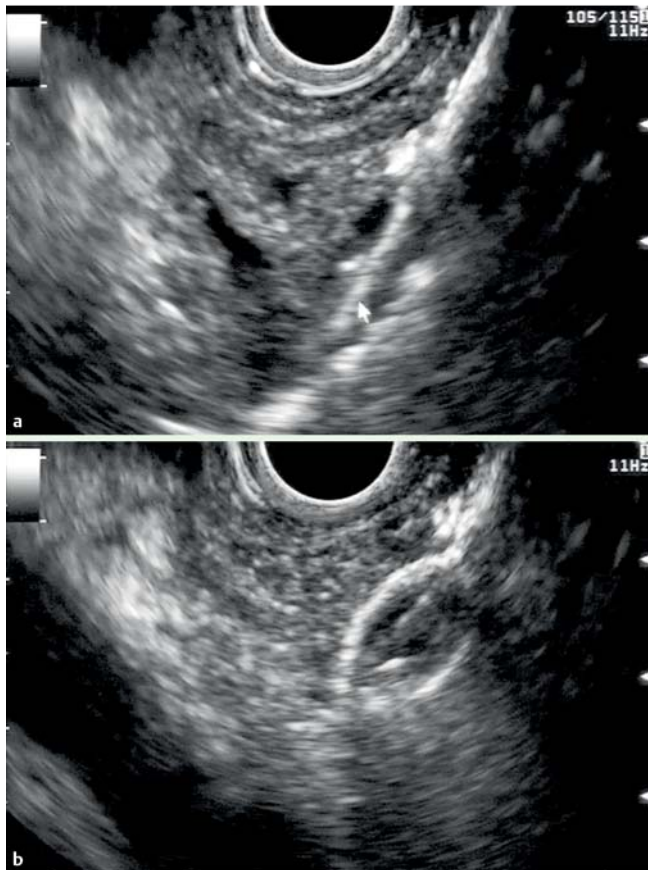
Placement of a lumen-apposing metal stent (LAMS). a Endoscopic ultrasound (EUS) image of the HotAXIOS catheter (9 Fr; Boston Scientific, Marlborough, Massachusetts, USA), energized and inserted inside the pancreatic duct. b EUS-guided deployment of the distal end of the LAMS (6 × 8 mm, HotAXIOS). Image shows the LAMS distal flange located inside the pancreatic duct.
